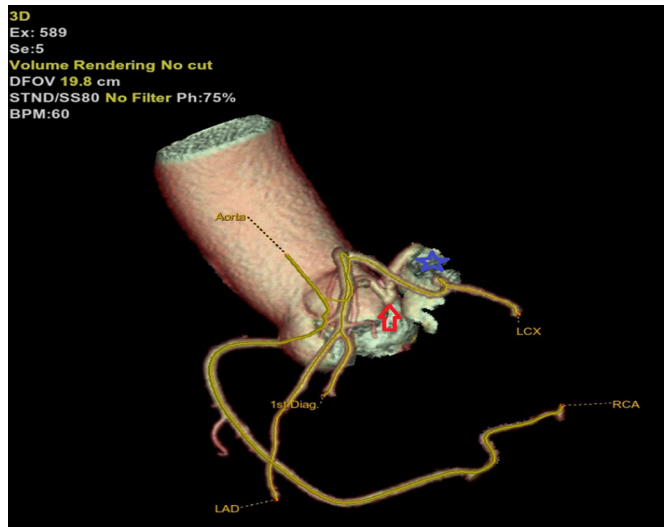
Case 2. Three-dimensional volume-rendered CT image. Blue star: LAA; red arrow: GCV
